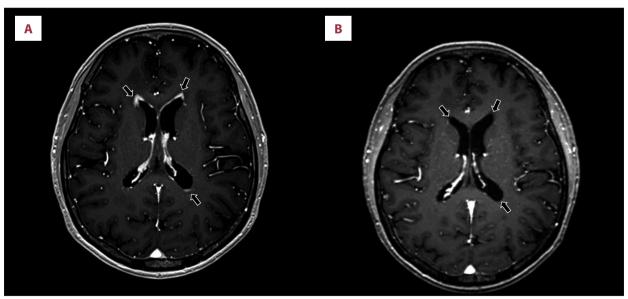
(A) Brain magnetic resonance imaging (MRI) revealed enhancing lesions along the ependymal lining of the lateral ventricles.
